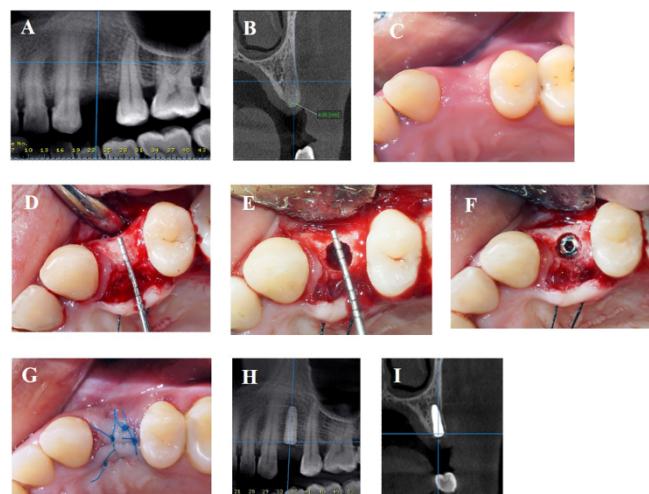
Shows series of photographs and radiographs of a patient who received an implant at a missing maxillary left first premolar, associated with osseodensification technique. Series A and B, preoperative CBCT radiographs show the planned osteotomy site; (A) a panoramic view and (B) a cross-sectional view. Series C, an intraoperative preoperative photograph
